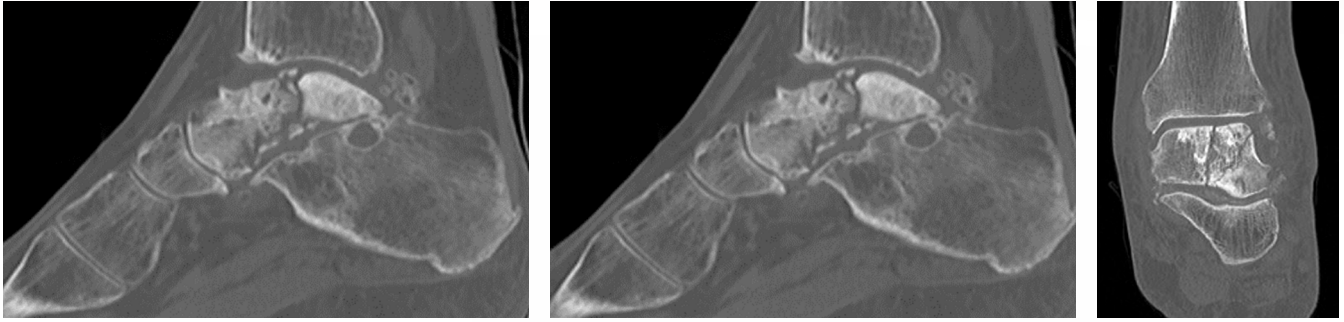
Pre-operative CT imaging reveals cyst formation and disease of the posterior subtalar joint together with sclerosis and fragmentation of the whole talus (global AVN)
